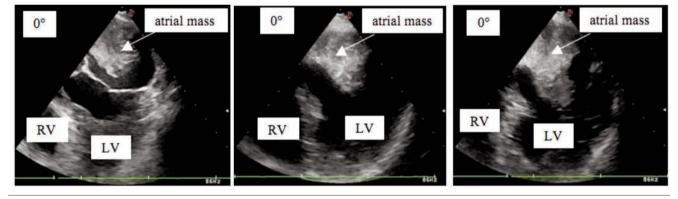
Transesophageal ecocardography, showing a peduncolate disomogeneous mass occuping the entire left atrium, with the extremities until the mitral valve plane (on dyastolic and systolic left atrium contraction). RV, right ventricle; LV, left ventricle.
